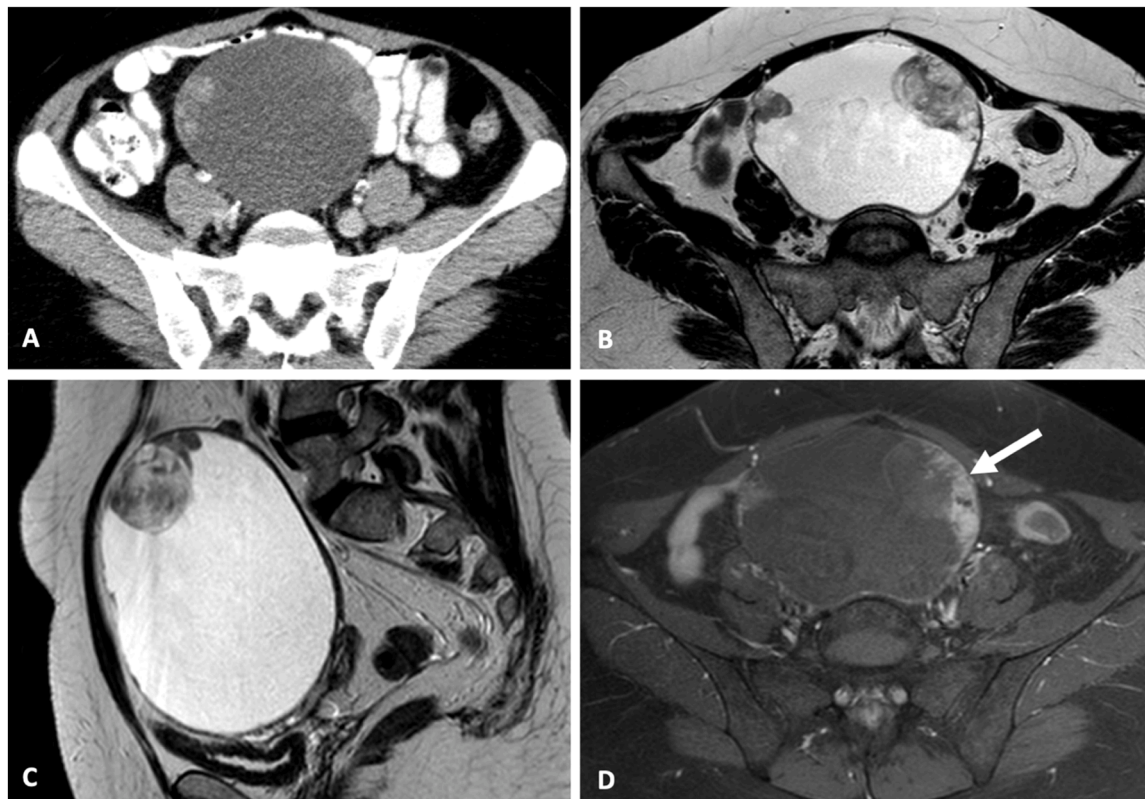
A ovarian clear cell carcinoma (OCCC) in a 51-year-old woman with symptoms of pelvic bulging. A, Axial contrast-enhanced computed tomography (CT) portrays a large well-defined unilocular cystic mass with many irregular peripheral solid protrusions (arrows), suspicious. B, C, Axial (B) and sagittal (C) T2 weighted image (WI), performed after 2 months, show a large unilateral, well-defined unilocular cystic mass with heterogeneous intermediate SI multifocal eccentric mural nodules. The signal intensity (SI) of the cyst is very high on T2WI. Compared to the previous CT, there is a notice of dimensional and numerical increase of parietal solid nodules, which show a greater degree of protrusion into the lumen. D, Axial enhanced T1WI with fat suppressed (FS) describes marked enhancement of solid nodules (arrow). During surgery, the left ovary was found to be occupied by an intraovarian predominantly cystic tumour with 6cm in the largest dimension. The pathological report showed a clear cell ovarian carcinoma, pT1apN0.
